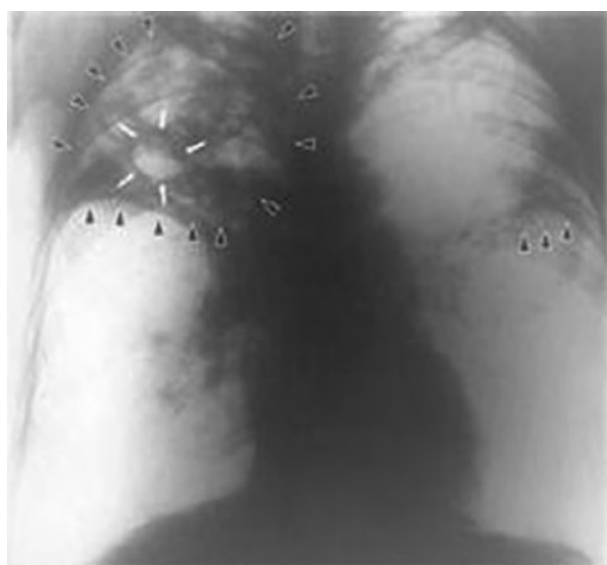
Chest X-ray with caverna in right lung, sclerosis in left lung (positive film image)
